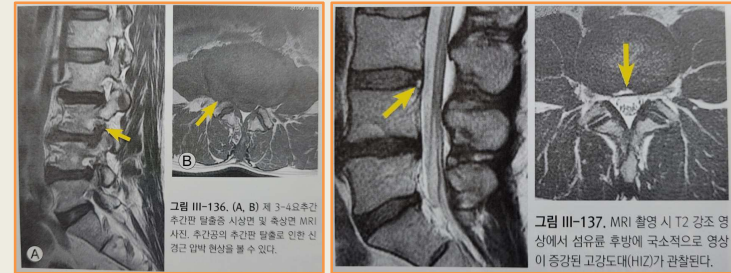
(A, B) 제 3~4추간판 추간판 탈출증 시상면 및 축상면 MRI 사진. 추간판의 추간판 탈출증으로 인한 신경근 압박 현상을 볼 수 있다.
